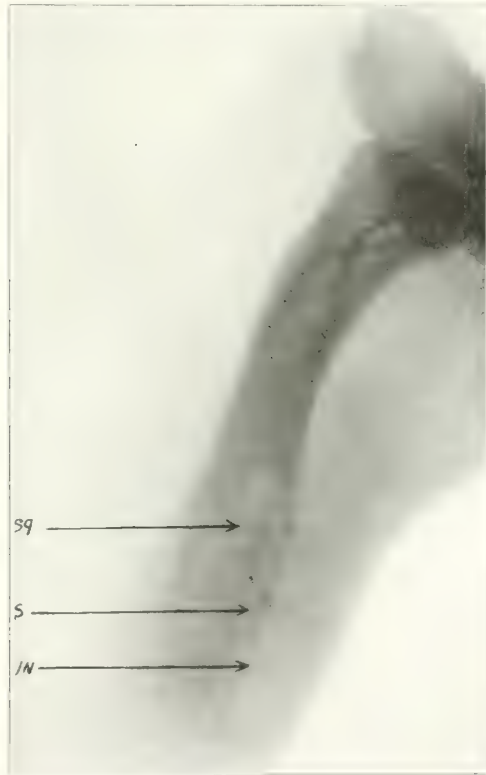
Following insertion of capillary tube containing croton oil, in medullary canal, Sept. 21, 1920. Roentgen ray. Large sequestrum in upper half of humerus, Oct. 15, 1920.
